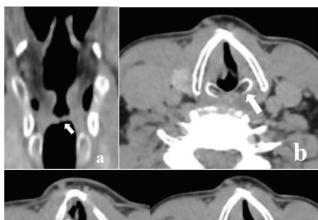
CT larynx of 57 years old male
